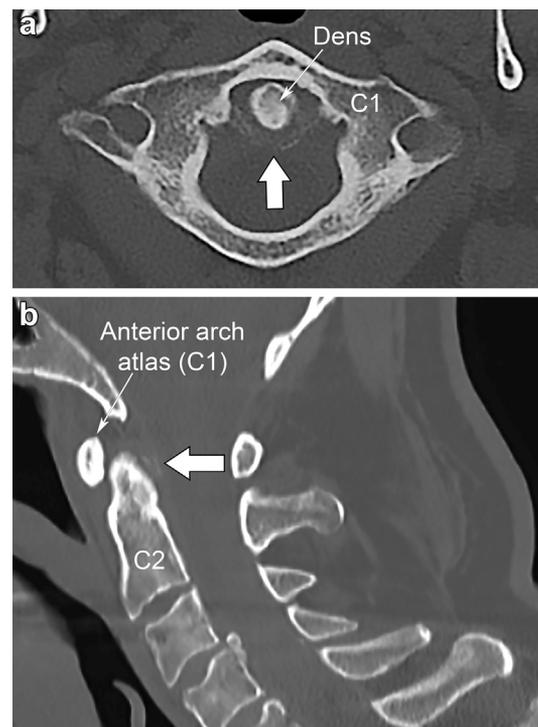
Computed tomography of the cervical spine. a) Axial view shows linear calcification (arrow) in the transverse ligament of the atlas consistent with crowned dens syndrome. b) Sagittal view shows calcification surrounding the dens (arrow).
